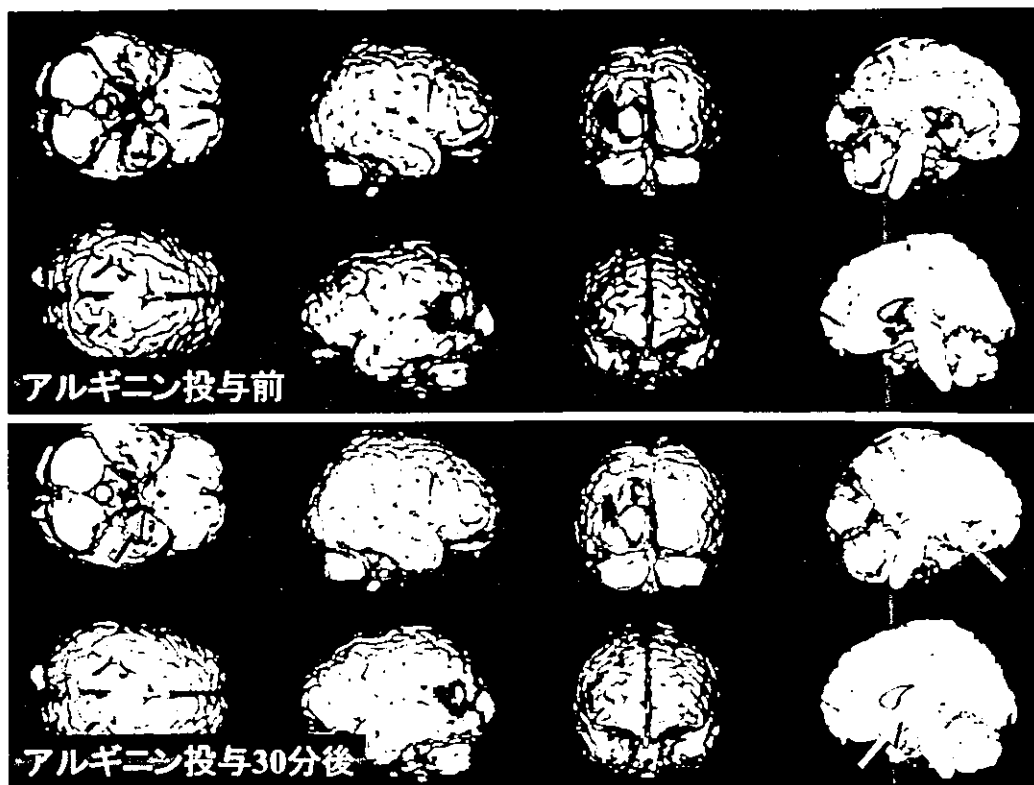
L-アルギニン投与前後のSPM-SPECT画像
